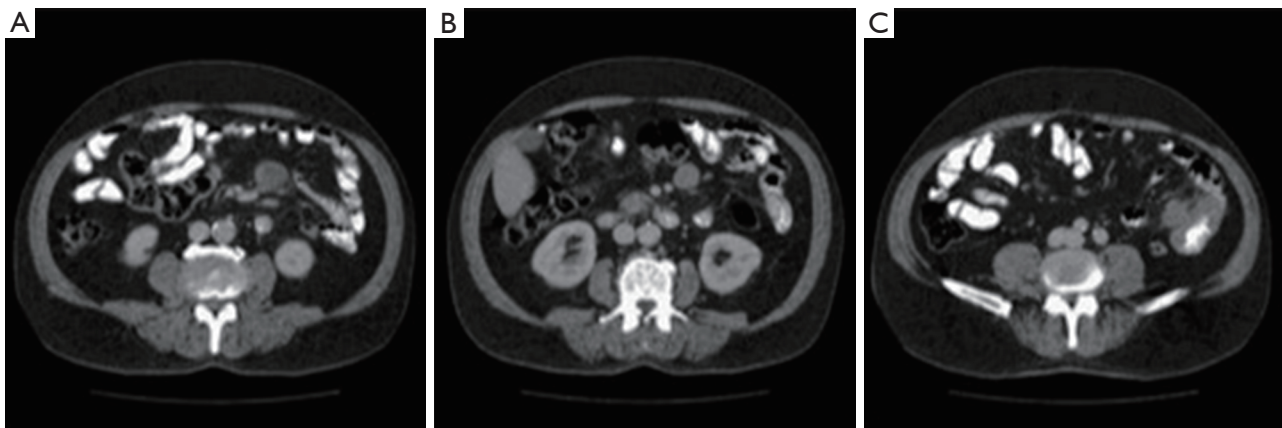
Abdominal CT demonstrating annular small bowel thickening and mesenteric lymphadenopathy.
